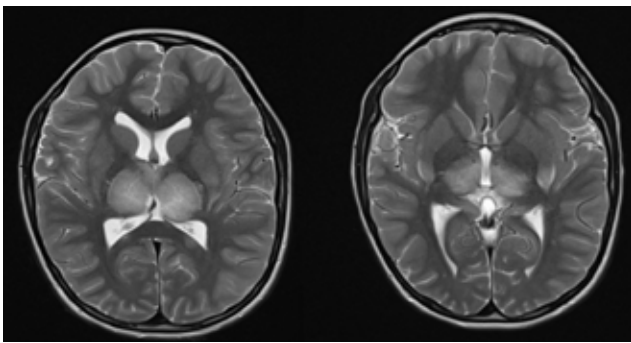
MRI findings of the endocranium of patient 3: Ddisseminated frontoparietal supratentorial white matter lesions and lesions in the brainstem, basal ganglia and cerebellum
